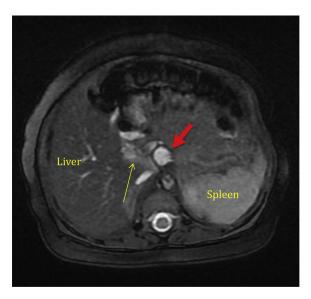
Axial T2 weighted MRI of the upper abdomen. The red arrow points to the dermoid cyst, immediately posterior to the SMV and SMA. The yellow arrow points to the duodenum.
